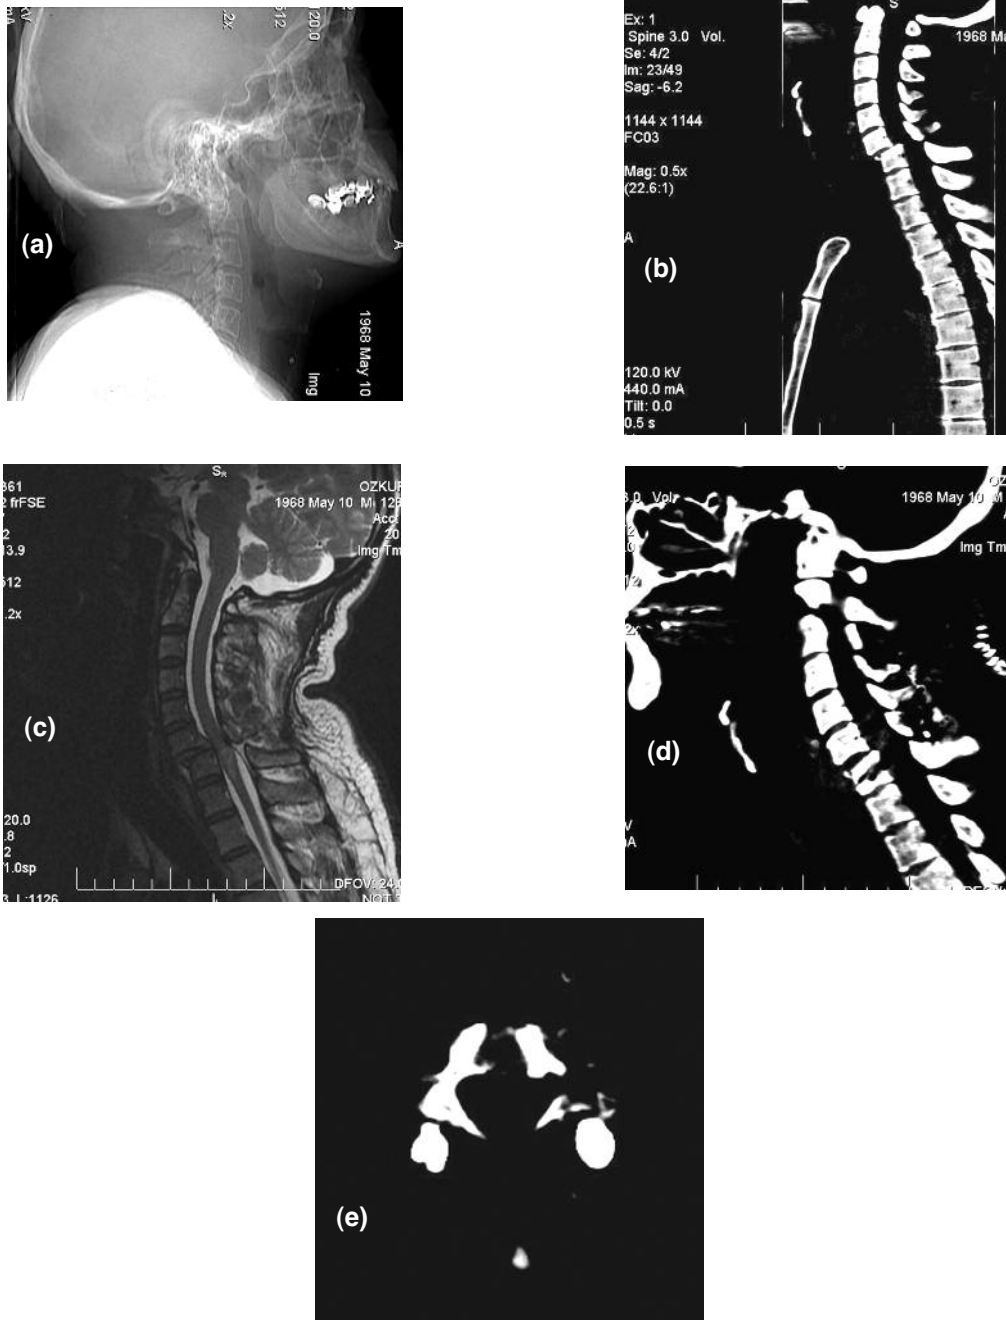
Case 1. Imaging studies obtained in a 44-year-old man with a fracture-dislocation at the level of C6-7. Preoperative direct X-ray (a) and sagittal CT scan (b) showing fracture-dislocation in C5-C6 level (c) Sagittal T2-weighted MR image demonstrating hyperintense signal due to edema and traumatic pseudoherniation. (d) Postoperative lateral CT scan showing posterior fixation with transpedicular screw/rod system. (e) Postoperative CT scan demonstrating accurate pedicle screw placement in C7 bilaterally.
